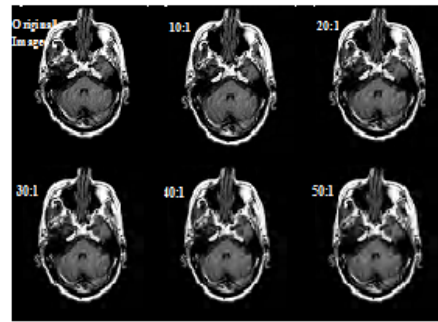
Comparison between original and compressed MRI Brain images
